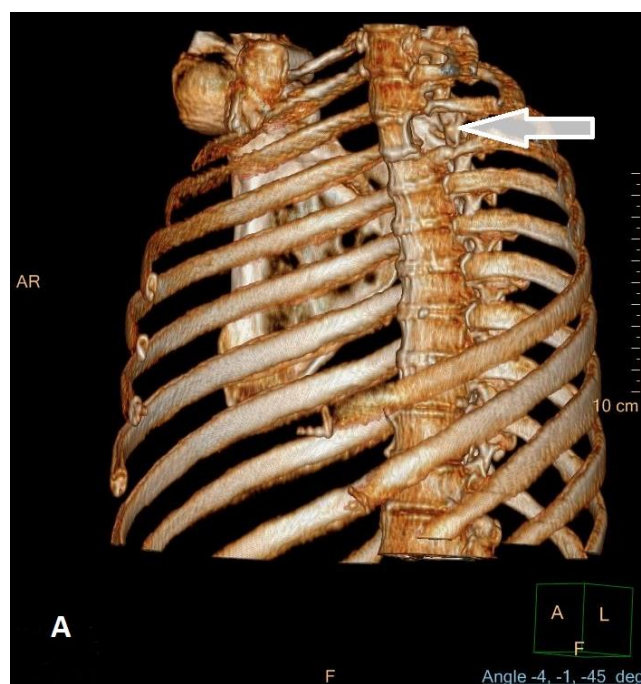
Three-dimensional computed tomography scan showing expanding cystic mass (white arrows) at T4 level and destruction of vertebral body
